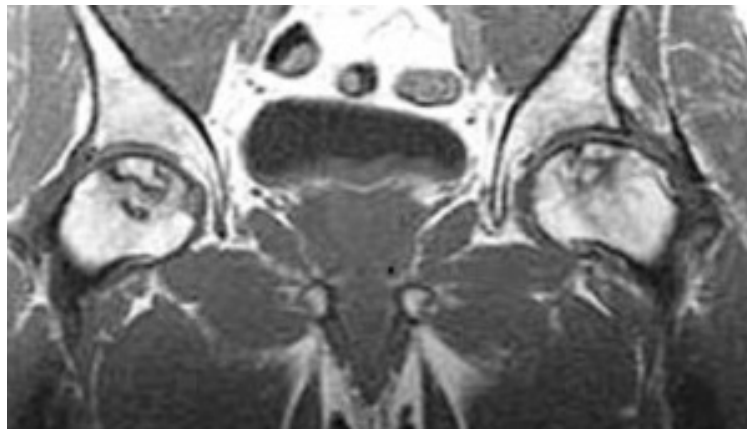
The MRI of the hip joint. Bilateral femoral head osteonecrosis , more extensive in the right hip
